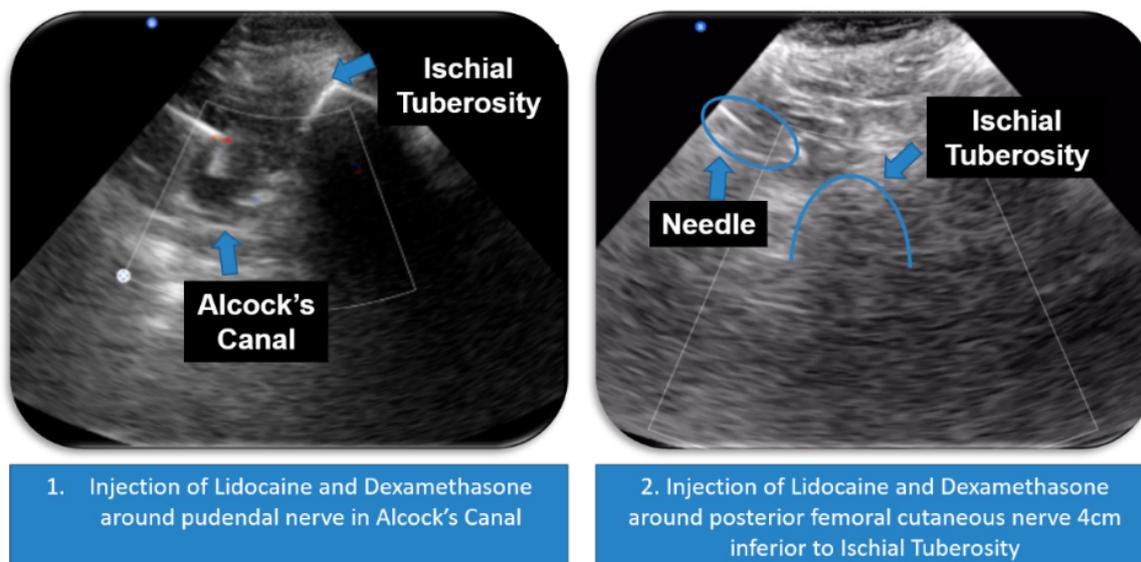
Ultrasound images of Alcock's canal and obturator canal. (1) Injection of Lidocaine and dexamethasone around pudendal nerve in Alcock's canal. (2) Injection of Lidocaine and dexamethasone around posterior femoral cutaneous nerve 4 cm inferior to ischial tuberosity.
